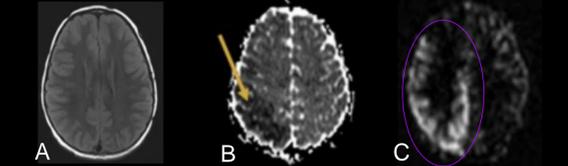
7-year-old male presenting in status epilepticus. No FLAIR abnormality observed (A). ADC map shows restricted cortical diffusion (B) and corresponding hyperperfusion is appreciated on PASL (C).
